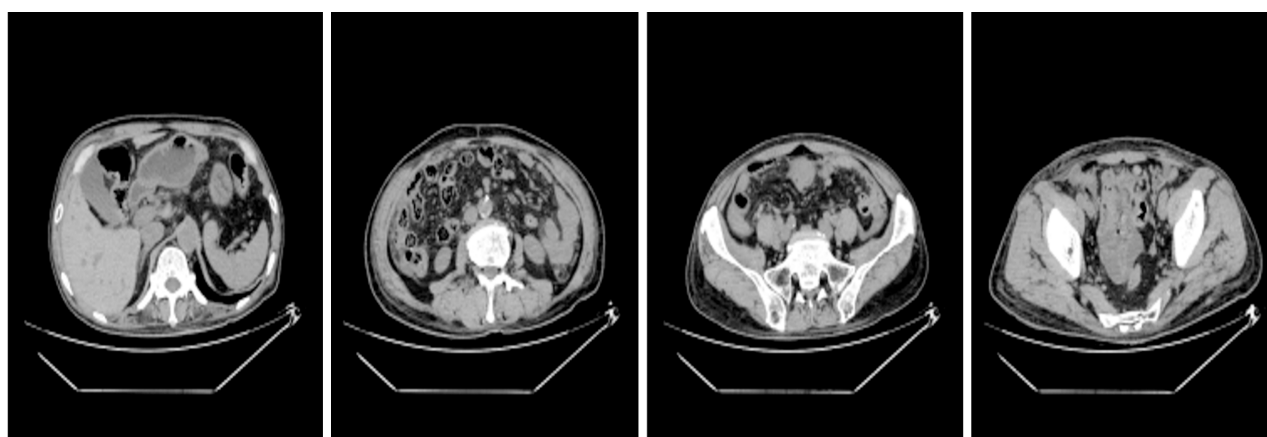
Abdominal computed tomography after treatment. It shows the tumor load is alleviated obviously with good therapeutic effect.
